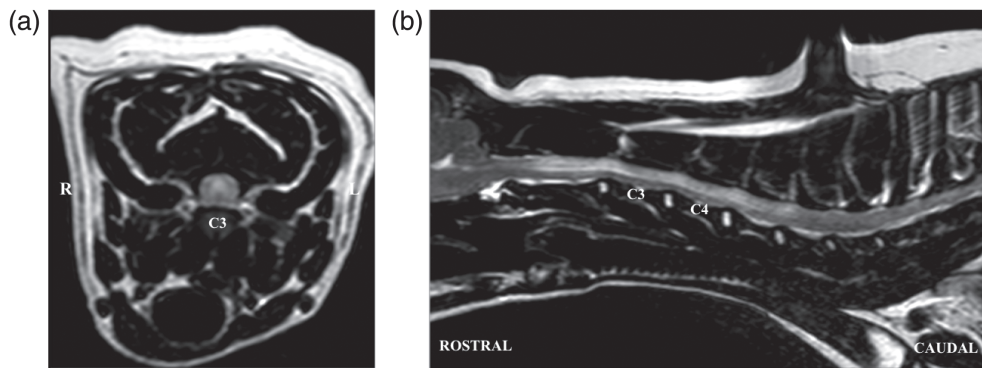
T2W transverse (a) MR image of the vertebral column and spinal cord at the level of C3, and mid sagittal (b) MR image of the cervical and cranial thoracic vertebral column and spinal cord of a 56-month-old Jack Russell terrier. There is a large, ill-defined, intramedullary hyperintensity extending from cranial C2 to cranial C6
